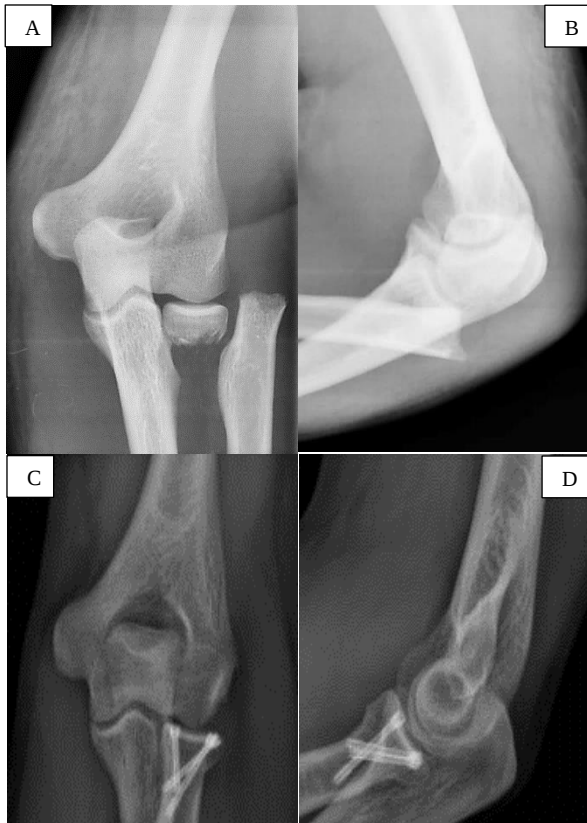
Pre-operation anteroposterior (AP) (A), pre-operation lateral (B), post-operation AP (C), and post-operation lateral (D) plain radiographs of a 39-year-old man's left elbow after tripod technique surgery
